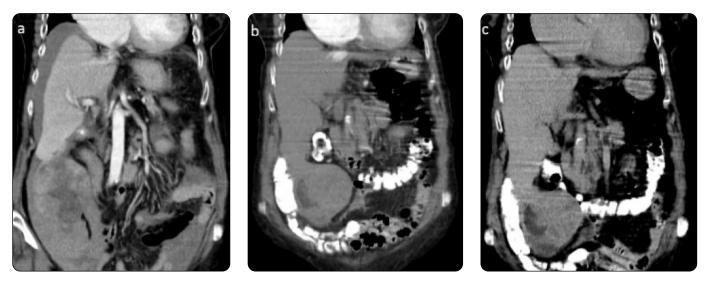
Abdominal CT with contrast medium and coronal sections. Prolongation of the right hepatic lobule is identified towards the right iliac fossa configuring Riedel's lobe. a) In arterial phase and in intimate contact with Riedel's lobule, solid lesion of defined edges and hypervascular with mosaic pattern due to the areas of necrosis in its interior. b) Venous phase: wash out. c) Peripheral capsule in late phase.
